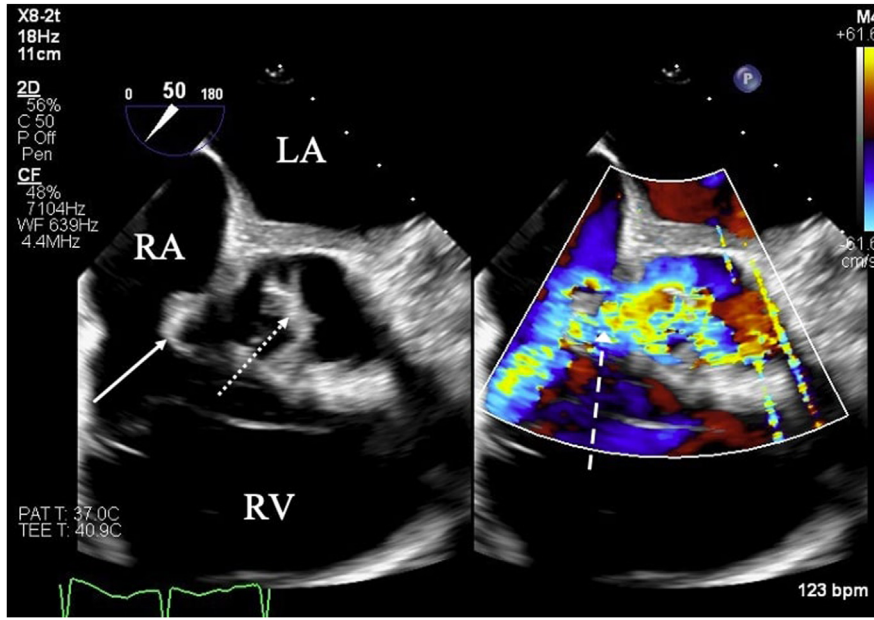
Two-dimensional TEE, midesophageal short-axis (50°) view without (*left*) and with (*right*) simultaneous color-flow Doppler demonstrates both the aortic valve vegetation (*dotted arrow*) and the adjacent RA vegetation (*solid arrow*) with the associated Gerbode defect with continuous flow from the LV outflow tract to the RA (*dashed arrow*). LA, Left atrium; RV, right ventricle.
